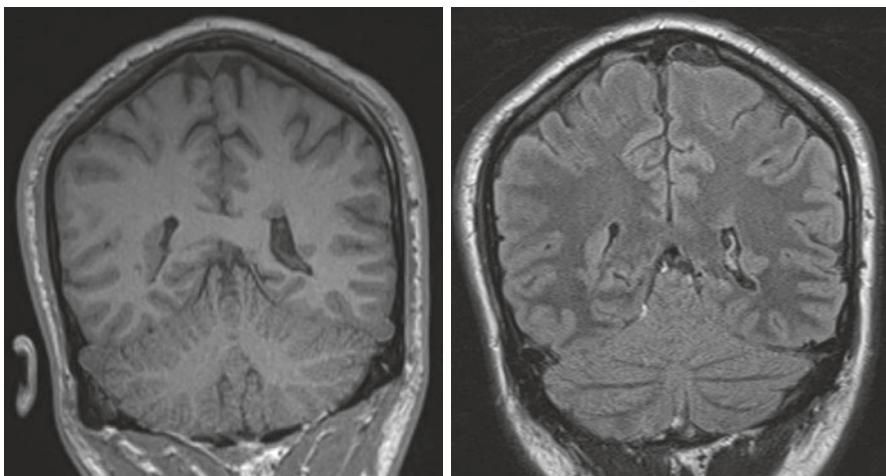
Coronal T1 and T2 FLAIR images showing bilateral periventricular heterotopia in a 25-year-old man with drug-resistant epilepsy
